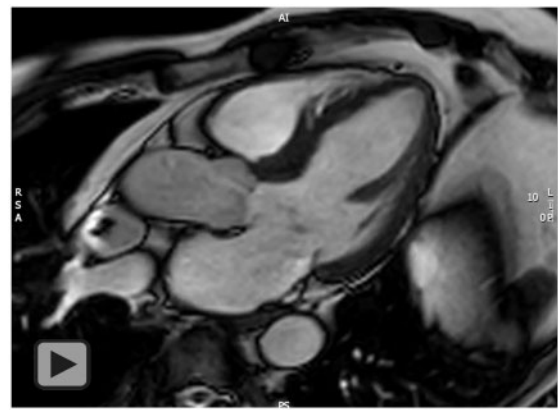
End-diastolic cine (upper panels) and late gadolinium enhancement (lower panels) cardiovascular magnetic resonance images in basal short-axis and three-chamber views acquired in 2018 and at present evaluation (2020). In 2018, marked septal hypertrophy (max. 17 mm) as well as non-ischaemic late gadolinium enhancement, with a sub-epicardial distribution in the basal antero-septum (arrows) together with a diffuse, intramural late gadolinium enhancement in the basal inferoseptal, inferior and inferolateral segments (arrow heads) can be seen. At present evaluation, an obvious decrease in the extent of hypertrophy (max. 13 mm) as well of late gadolinium enhancement is noted together with a pace-maker lead in the right ventricle.
